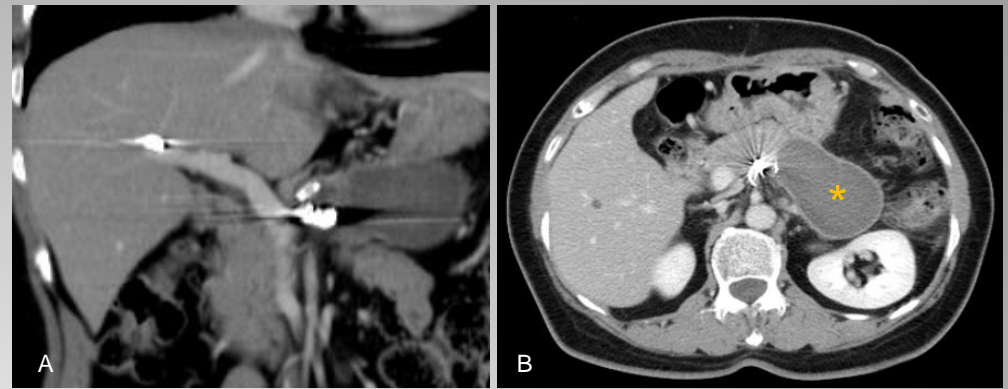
(A) Reformatted coronal CT image demonstrate a migrated coil in the right branch of portal vein. (B) Axial CT image after transarterial embolization shows non-opacified thrombosed pseudoaneurysm (asterisk) and coils in the splenic artery.
